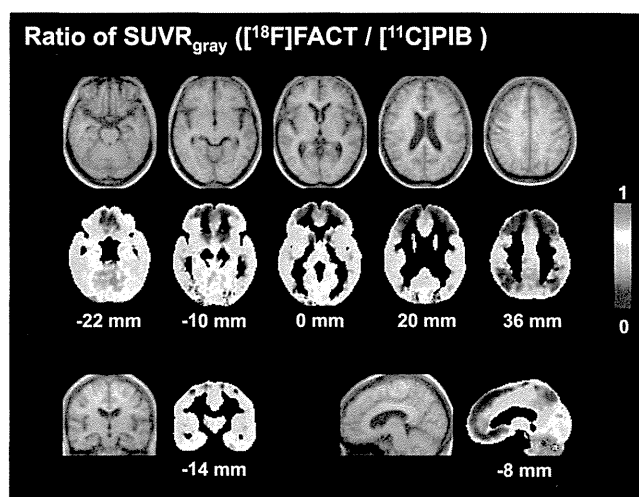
Average images of ratio of SUVR in gray matter ($SUVR_{gray}$) of [^{18}F]FACT to [^{11}C]PIB studies for AD patients and corresponding average MR images (T1-weighted images). Scale maximum and minimum values are 1 and 0 of ratio. All transaxial images are parallel to the anterior-posterior commissure (AC-PC) line. Slice positions are -22, -10, 0, 20, and 36 mm from the AC-PC line. Anterior is at the top of the image and the subjects' right is on the left. The coronal image is perpendicular to the AC-PC line and its slice position is -14 mm (posterior side) from the AC. The subjects' right is on the left of the image. The sagittal image is parallel to the AC-PC line and its slice position is -8 mm (left side) from the AC-PC line. Anterior is on the left of the image
